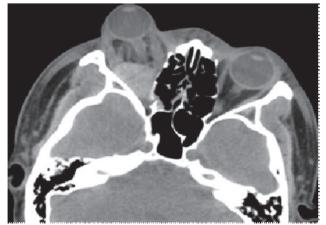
Admission axial orbital computed tomography scan reveals right orbital apex hematoma
